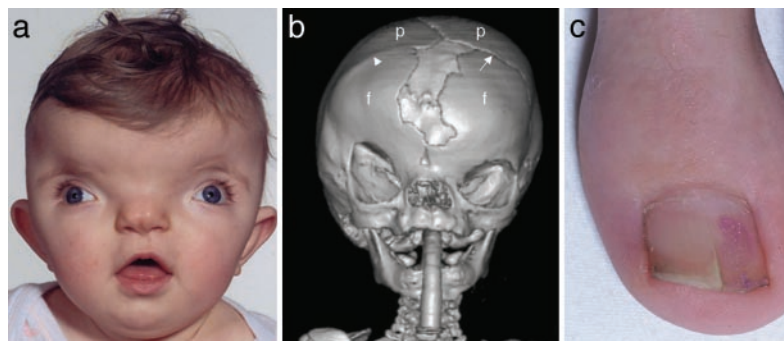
Clinical features of CFNS. (a) Facial view showing marked hypertelorism, divergent squint, and central nasal groove (subject ID, 1593; age, 1 year). (b) Three-dimensional computed tomographic skull reconstruction (subject ID, 3167; age, 8 months) showing right unicoronal synostosis, lateral displacement of orbits, and central defect between frontal bones. Note bony ridge at site of obliterated right coronal suture (arrowhead); the left coronal suture is patent (arrow). f, frontal bone; p, parietal bone. (c) Longitudinal splitting of the nails is frequent.
